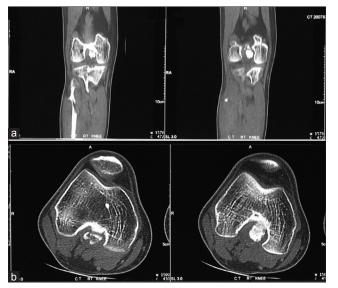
(a) Coronal section of computed tomography scan of the right knee showing bony outgrowth in the intercondylar fossa of right femur. (b) Computed tomography scan transverse section right knee showing bony outgrowth in continuation with the cortex in the intercondylar fossa of right femur
